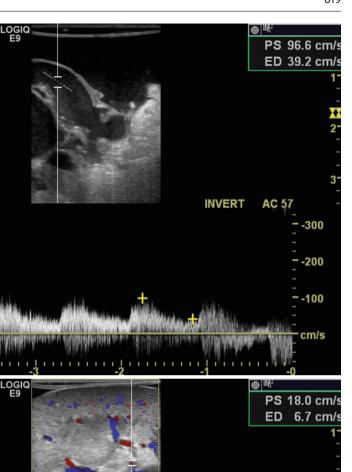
Intraoperative duplex sonography of main renal artery prior to repair in longitudinal (a) and transverse view (b). Post-repair duplex (c) with corresponding spectral waveform analysis and renal parenchymal signals (d)
